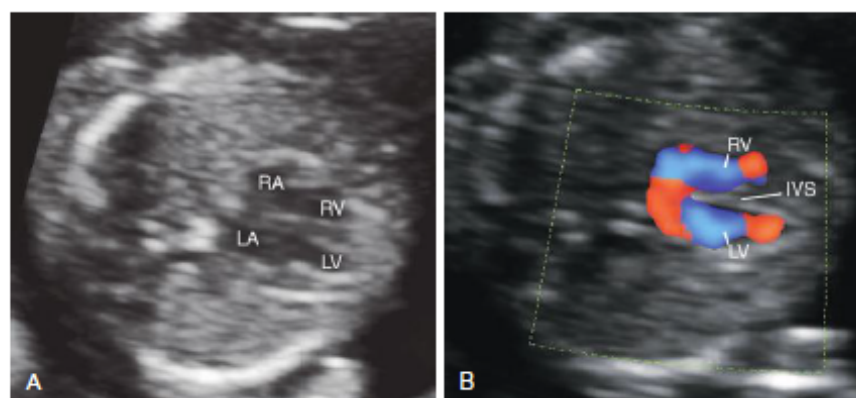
Four-chamber view in early gestation. (A) Four-chamber view in 13th week; (B) Four-chamber view with Doppler in 13th week.
